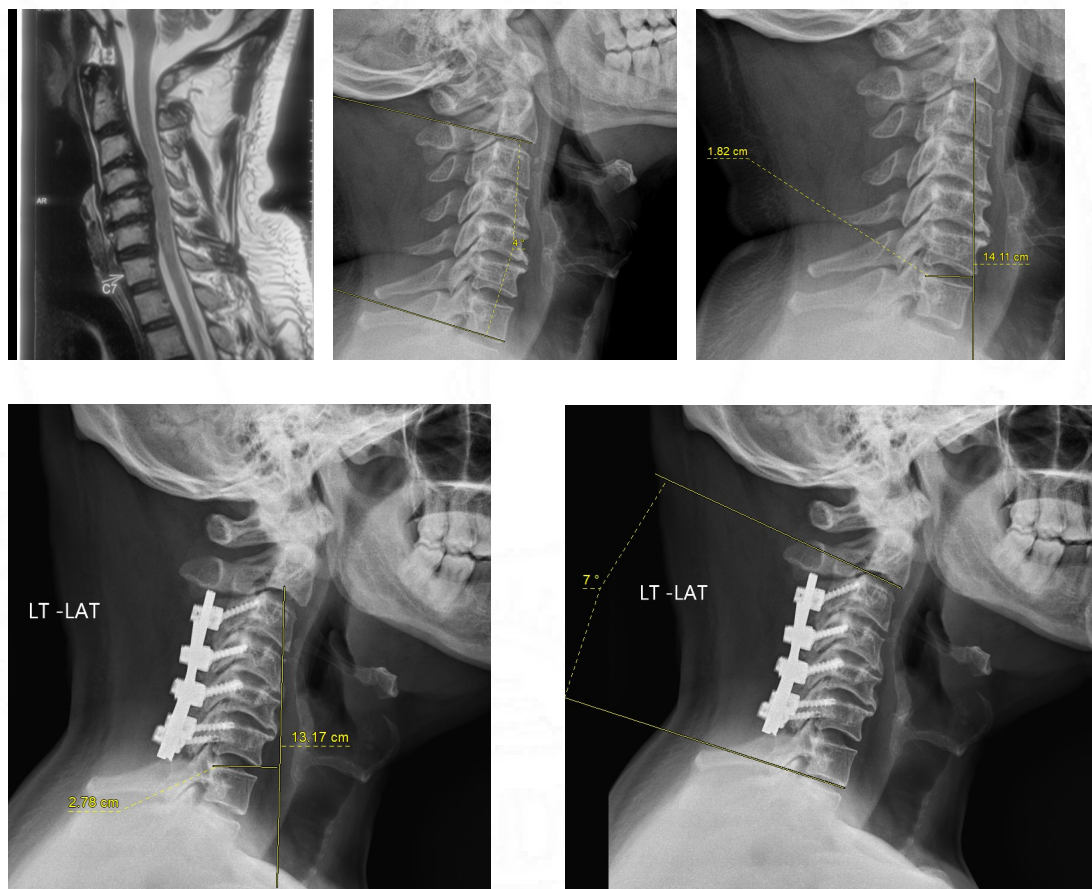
Pre-operative CT and MR images and post-operative lateral and AP radiographs of patient with a mixed type of OPLL
